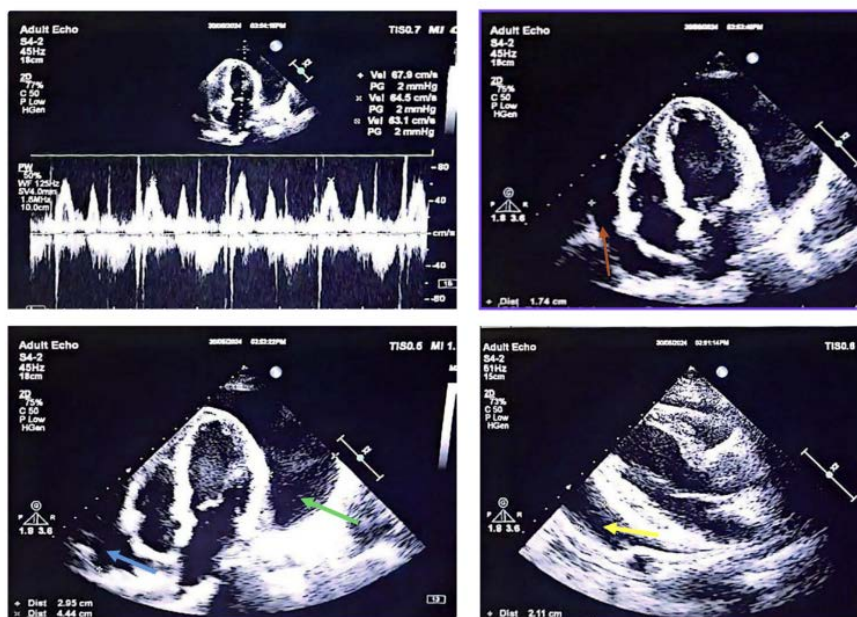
Echocardiography shows circumferential pericardial effusion. (Arrow: Orange: lateral LV, Blue: lateral RA, Yellow: Posterior LV, Red: Lateral RV)
